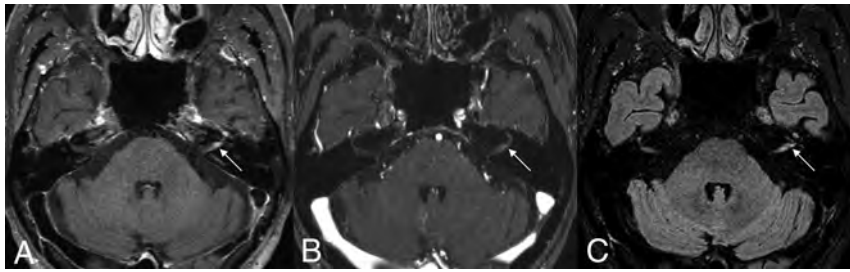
A 71-year-old man with left facial neuritis. Moderate enhancement noted at the left distal meatal segment of the facial nerves on 3D T1 TSE (A), but 3D T1 FSPGR (B) and 3D T2 FLAIR (C) revealed equivocal and mild enhancement, respectively, of the corresponding facial nerve (arrows).
